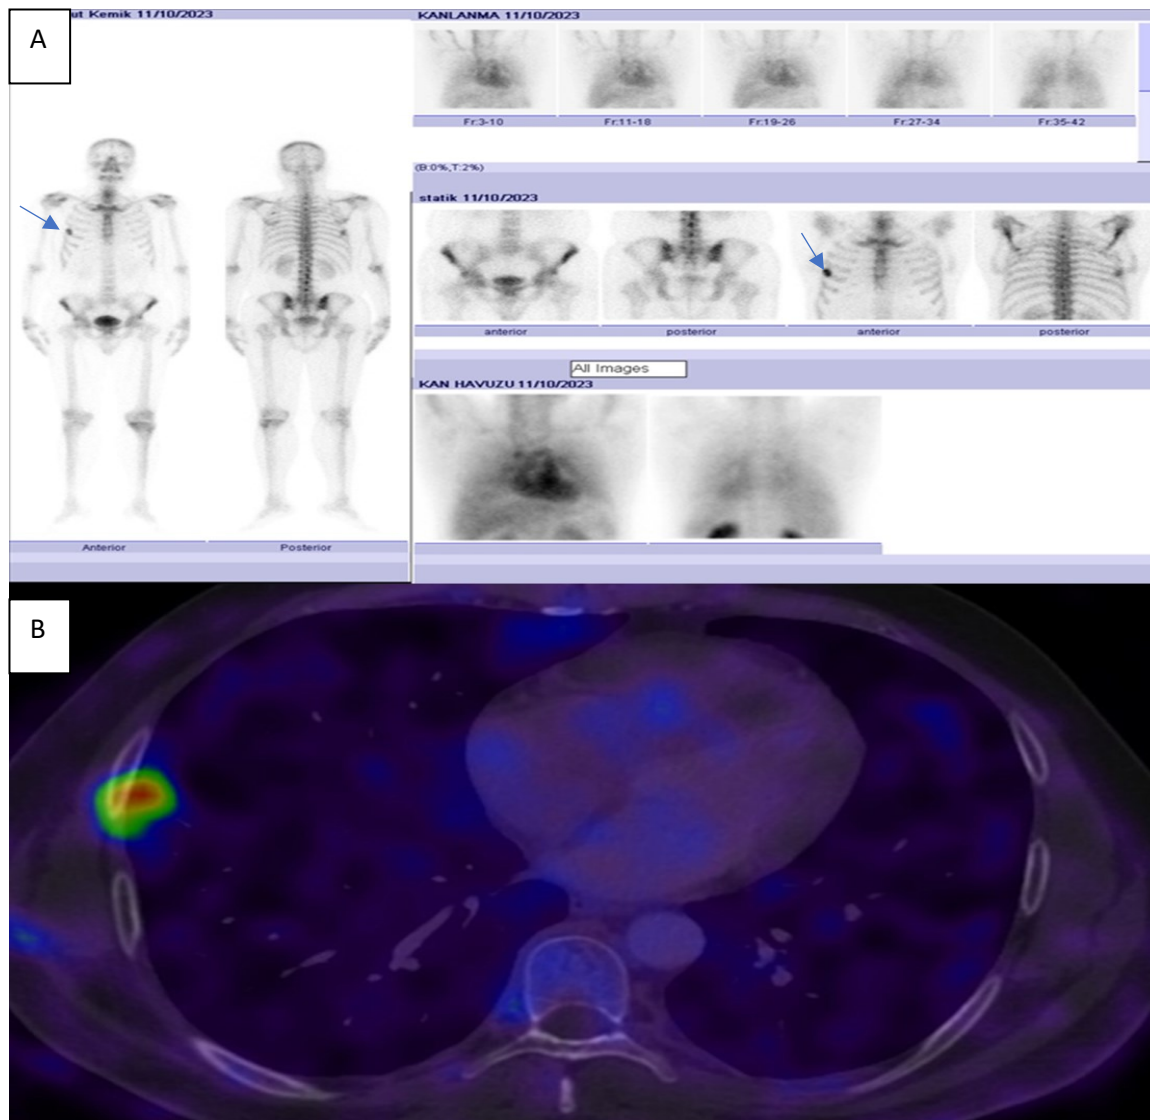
Planar whole body anterior posterior projection bone scintigraphy (A) and thoracal SPECT-CT imaging results (B) showing significantly increased bone tracer uptake at right 7th costae with pathological result concluding fibrous dysplasia.
